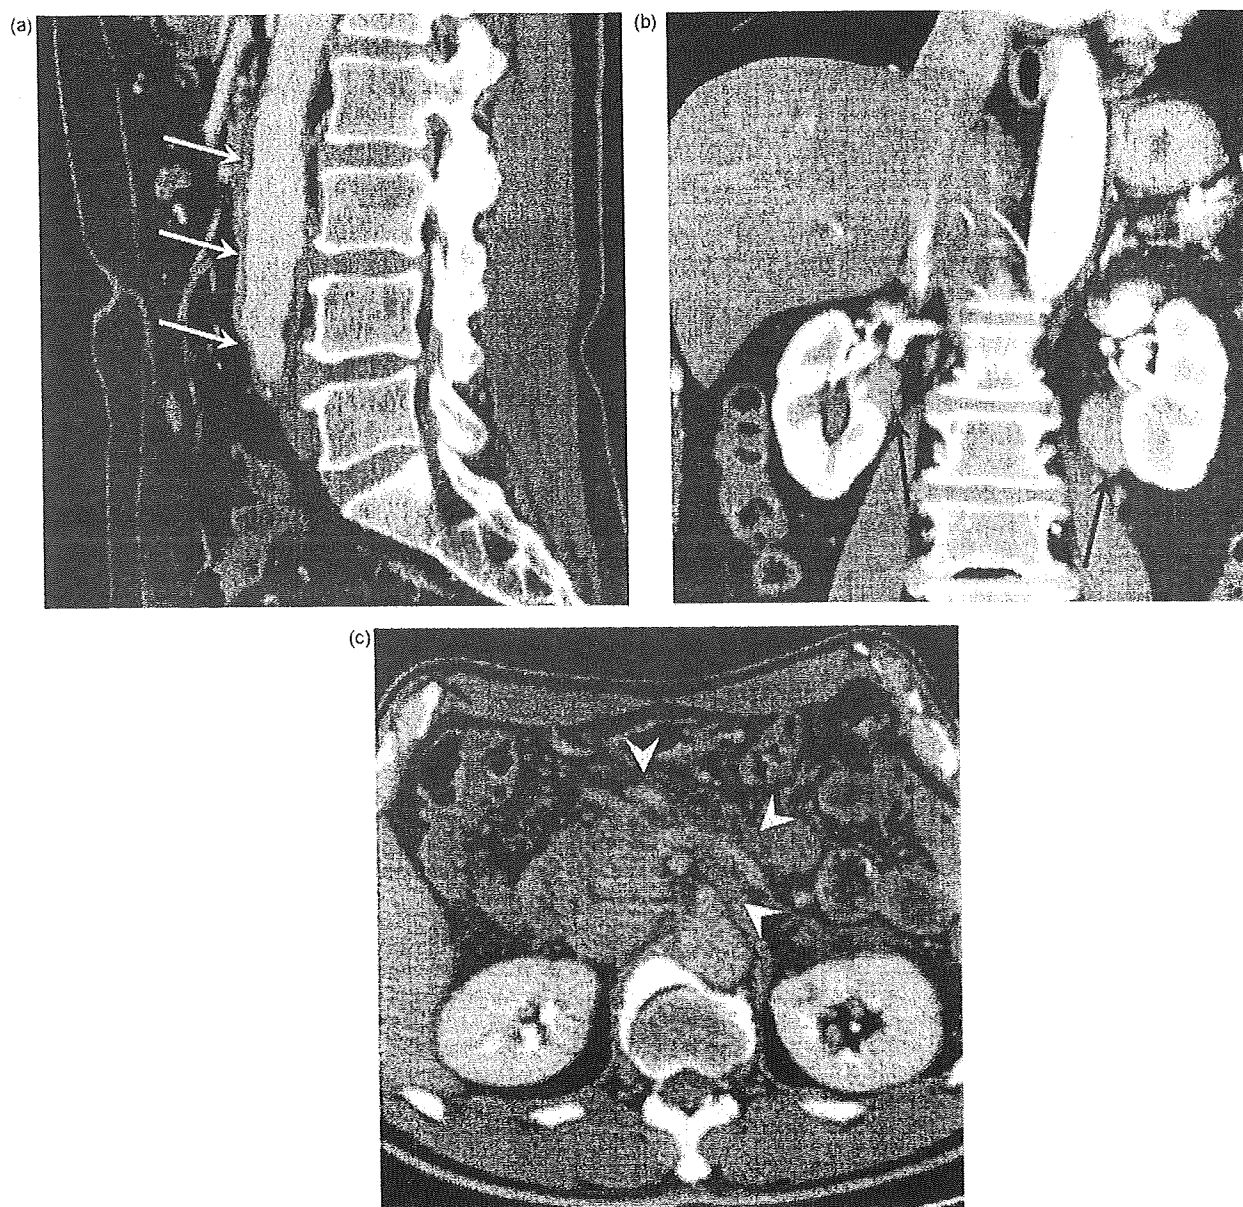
Retroperitoneal lesions. (a) Sagittal reformation of contrast-enhanced CT shows a soft tissue mass along the aorta (white arrows). (b) Coronal reformation of contrast-enhanced CT shows masses around both ureters (arrows). No hydronephrosis is observed. (c) Axial contrast-enhanced CT shows increased fat density around superior mesenteric artery and splenic vein (white arrow heads).
